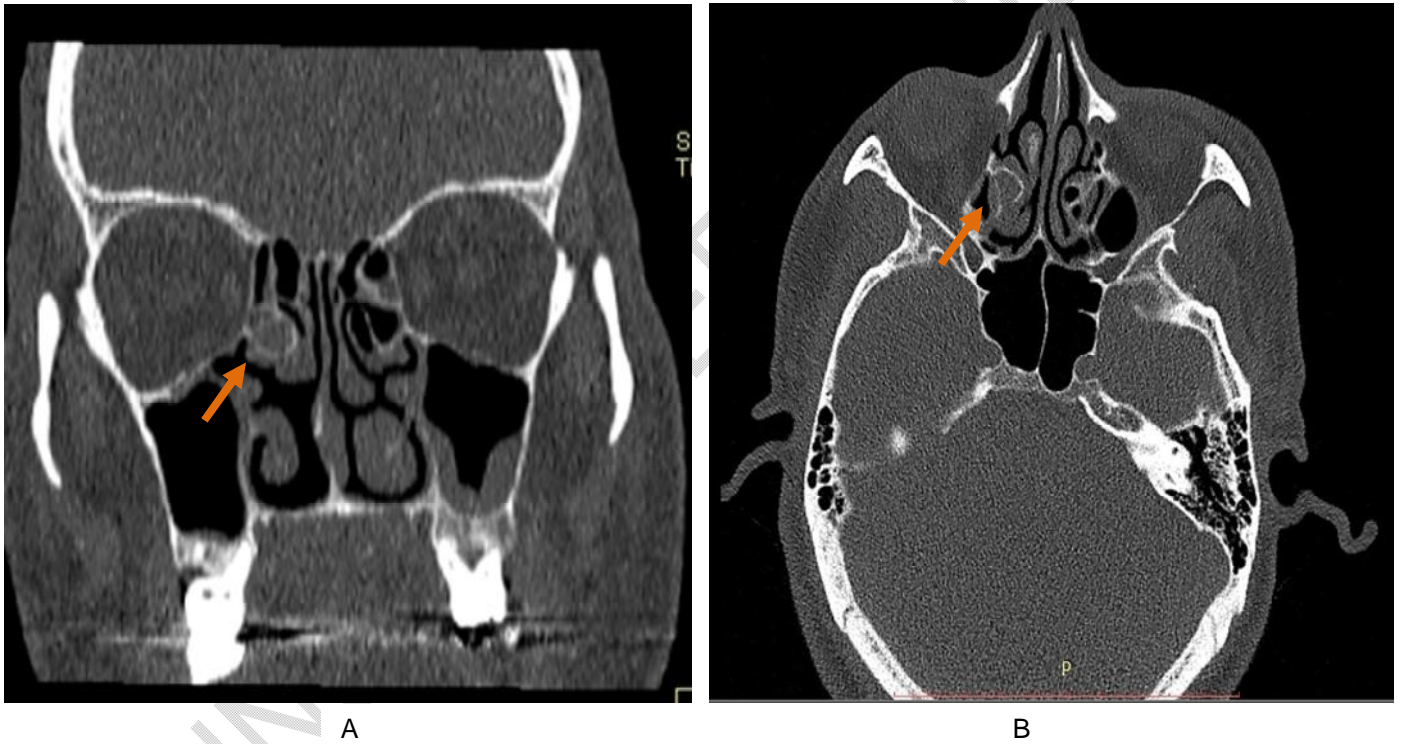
(A) Coronal view (B) Sagittal view of CT Paranasal Sinus bone window setting showing mass at the anterior ethmoidal air cells with focal hyperostosis
